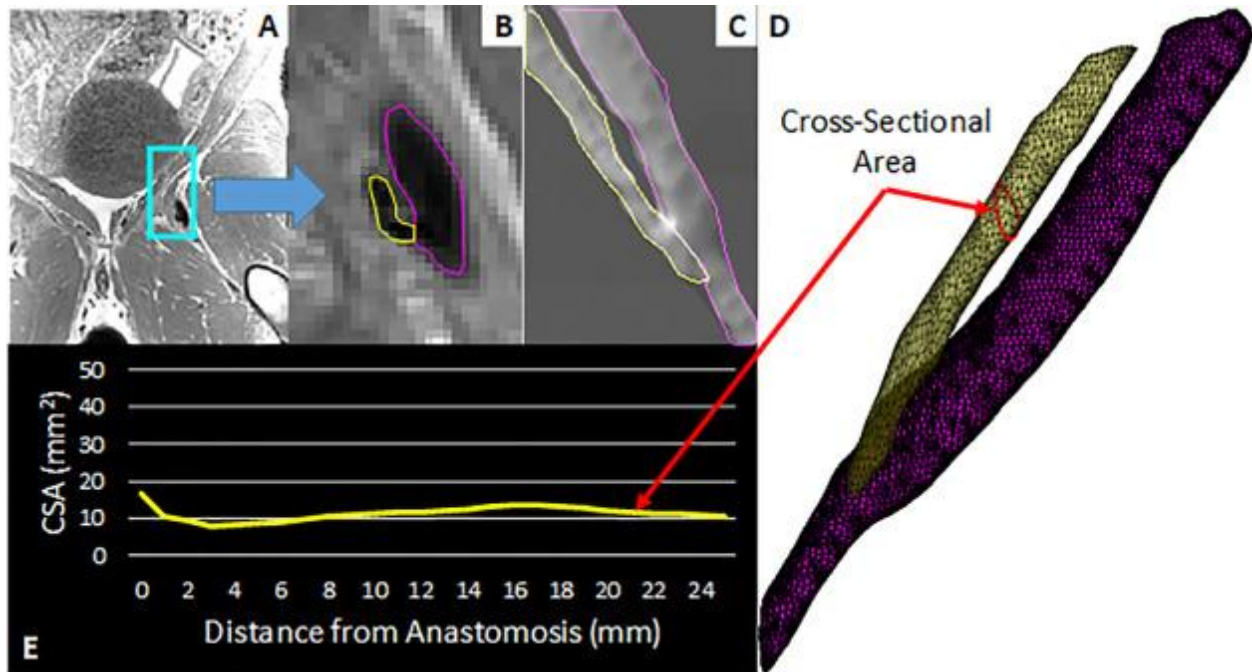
Steps to generate cross-sectional area. (A) Black-blood (BB) MRI was performed to image lumen geometry of the fistula. (B) Segmentation of the vein (yellow) and artery (magenta) outline using polar dynamic programming (PDP). (C) Cropped version of the 3D model that will be used to estimate centerline and cross-sectional area (CSA). (D) Mesh of the fistula; the red circle is the cross-sectional area at a distance of 20 mm from the anastomosis plane. (E) The CSA plot from 0 to 25mm from the anastomosis acquired on (D).
